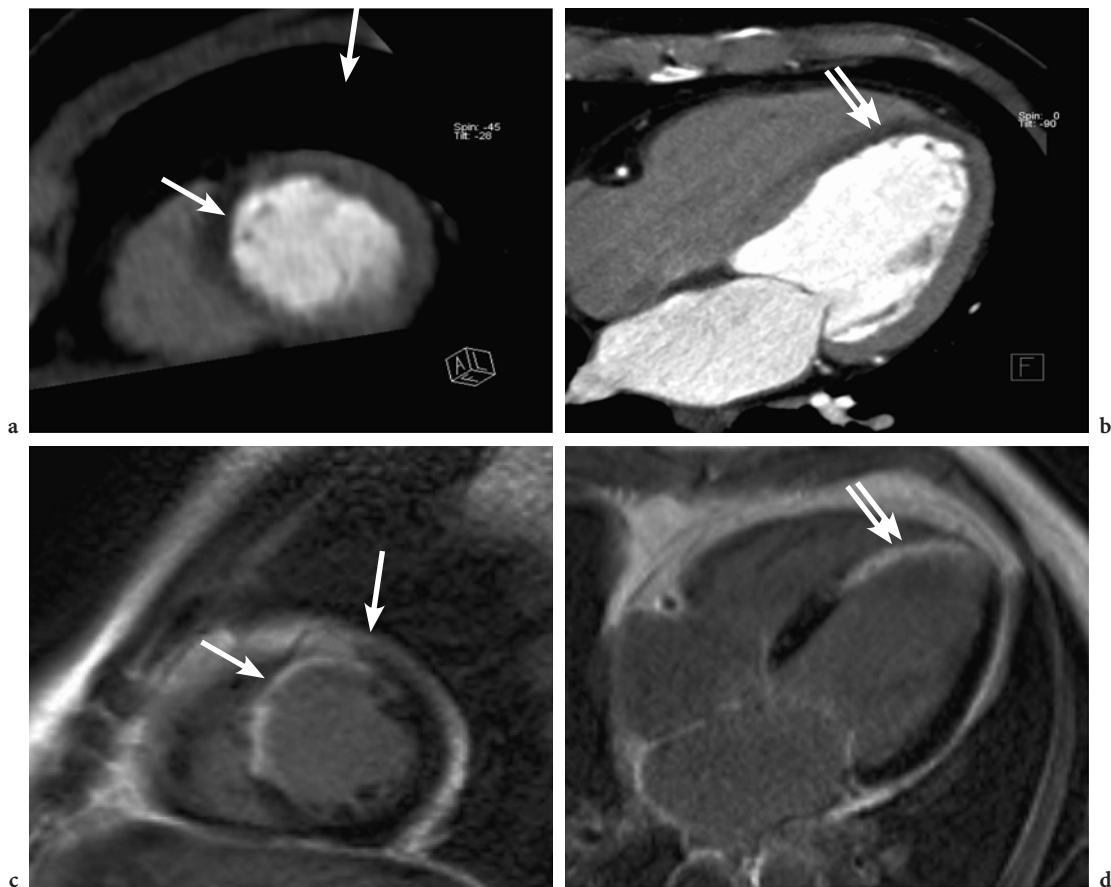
64-slice CT examination of a patient with suspected myocardial infarction, correlated with a late enhancement MRI study. a, b CT examination reveals perfusion defects (arrows, double arrow). c, d In the MRI study, the same territories show late enhancement indicating infarcted myocardium. Optimized administration of contrast agent delivers total wash-out of the right heart, thus eliminating contrast artifacts. (Case courtesy of Sarawak General Hospital, Kuching, Malaysia)
